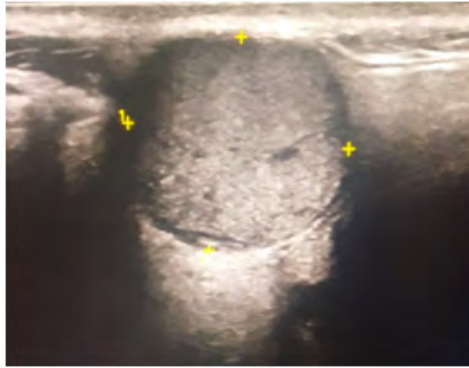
Right parotid ultrasound showing a well-circumscribed cystic mass with regular margins, posterior acoustic enhancement, and finely echogenic content. No color Doppler signal was detected within the lesion.
